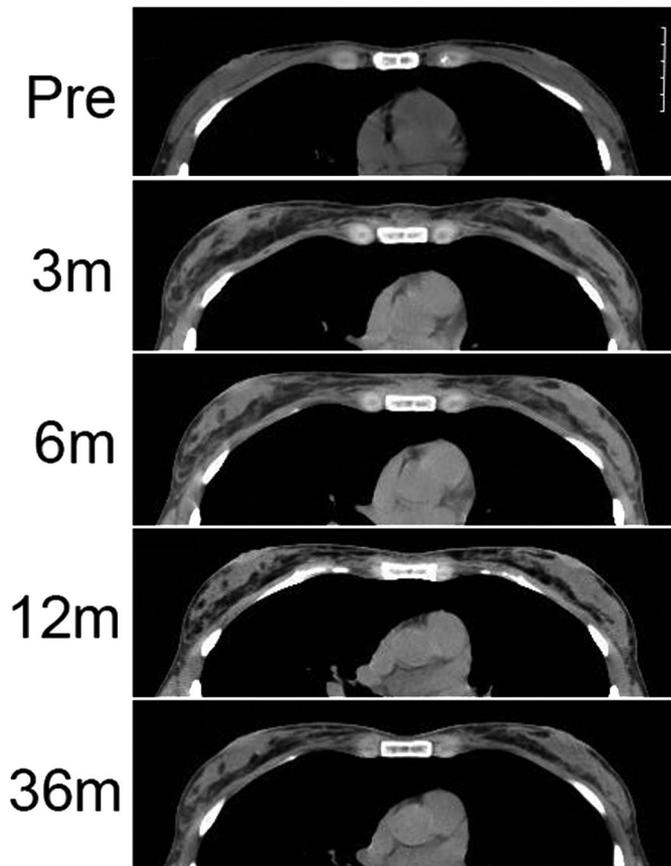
CT scan images taken before (Pre) and 3, 6, 12, and 36 months after treatment. Normal mammary glands and the thin fatty layers around them are visible before treatment. Substantial fibrosis had occurred, both diffusely in the transplanted fat surviving around the mammary glands and in the subcutaneous layer over the sternum, at 3 months. The fibrotic mass over the sternum was treated twice with local injections of triamcinolone acetonide at 6 and 8 months and dissipated, but diffuse fibrosis in the breasts remains at 36 months.
